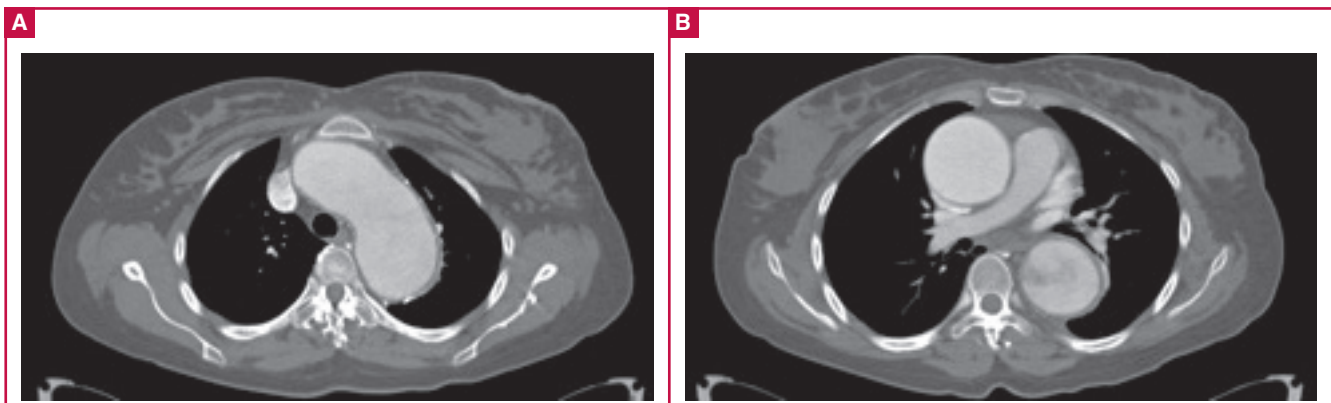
Axial CT post-contrast images in the arterial phase demonstrating aneurysmal dilatation of the arch of the aorta (A) and the ascending and descending aorta (B). Note the turbulent flow in the descending aorta.
